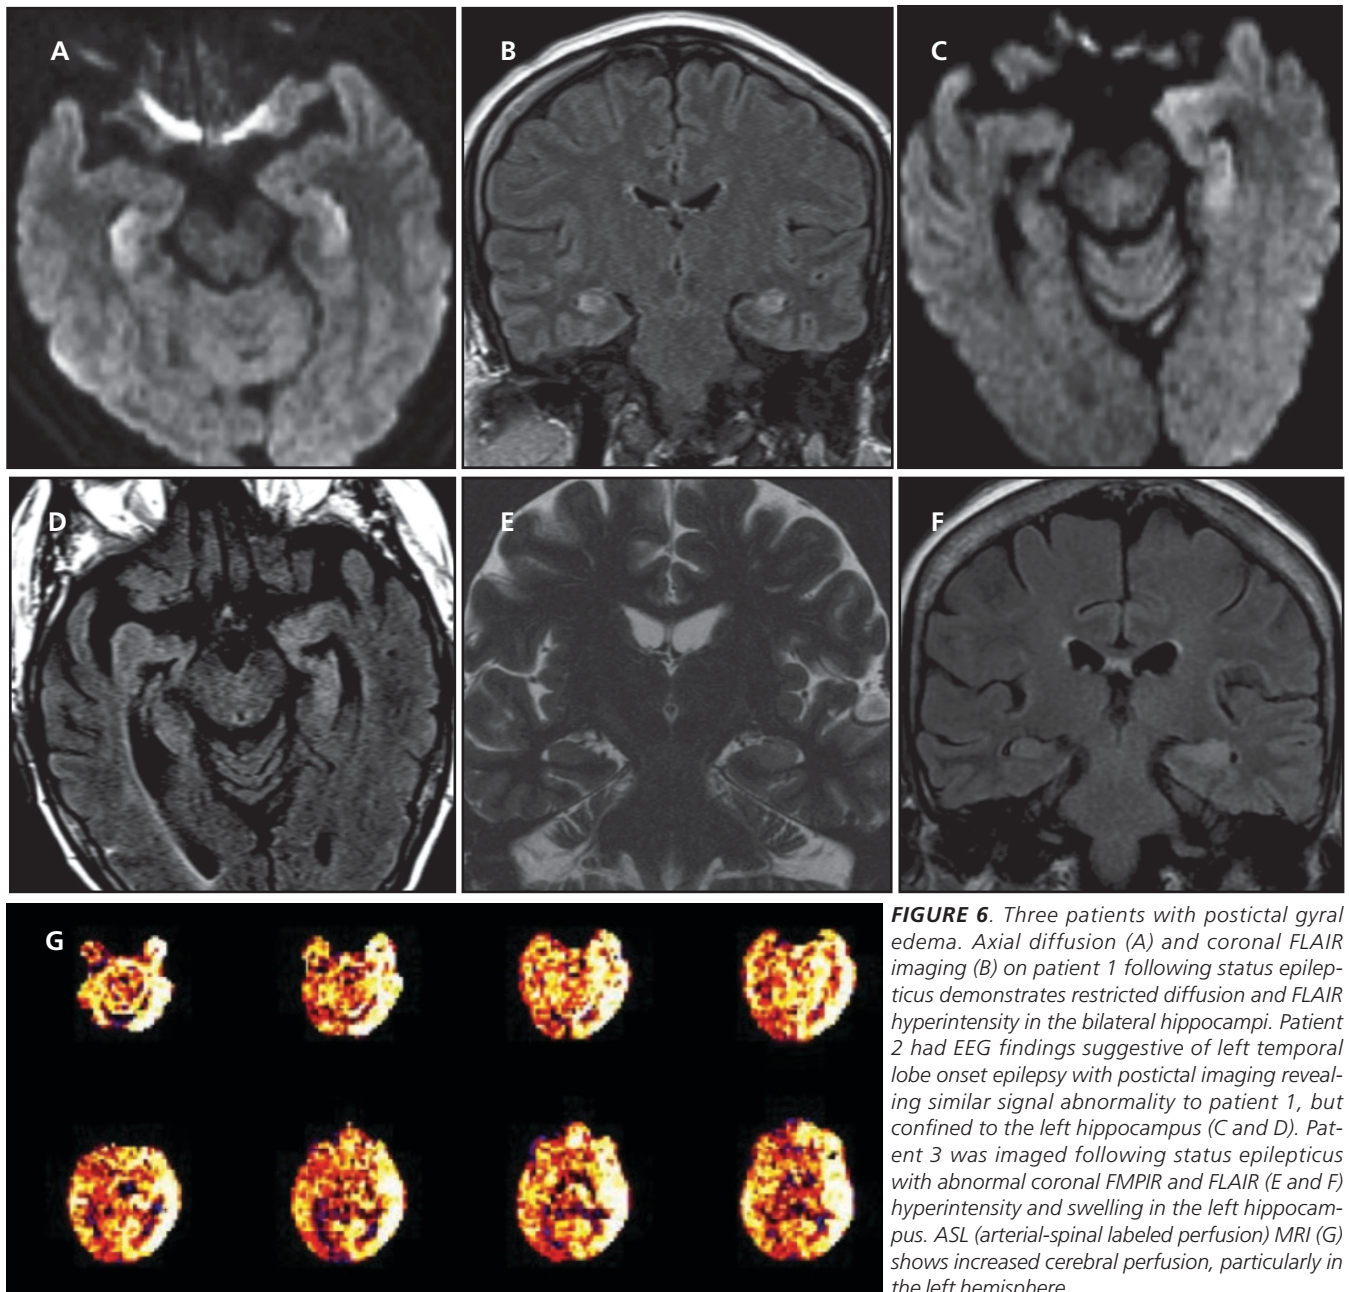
Three patients with postictal gyral edema. Axial diffusion (A) and coronal FLAIR imaging (B) on patient 1 following status epilepticus demonstrates restricted diffusion and FLAIR hyperintensity in the bilateral hippocampi. Patient 2 had EEG findings suggestive of left temporal lobe onset epilepsy with postictal imaging revealing similar signal abnormality to patient 1, but confined to the left hippocampus (C and D). Patient 3 was imaged following status epilepticus with abnormal coronal FMPiR and FLAIR (E and F) hyperintensity and swelling in the left hippocampus. ASL (arterial-spinal labeled perfusion) MRI (G) shows increased cerebral perfusion, particularly in the left hemisphere.
